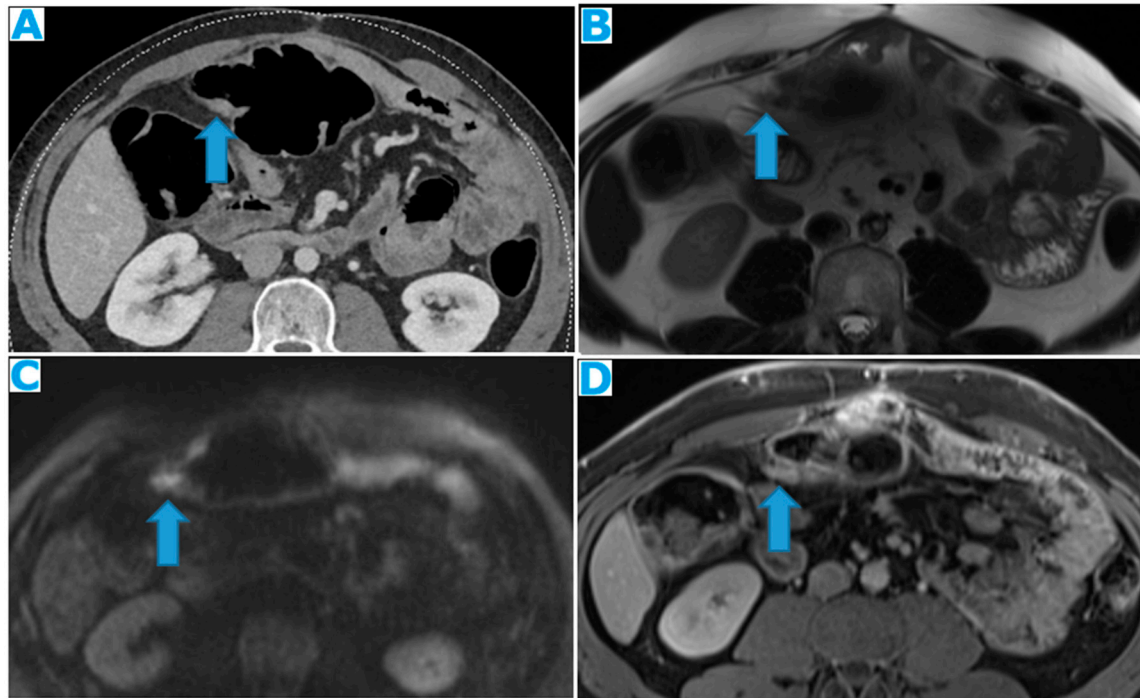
Axial CE-CT (A), axial T2WI (B), DWI (C), axial CE portal phase FST1WI (D). PC from gastric adenocarcinoma: Subtle deposit within the transverse mesocolon on CT, more conspicuous on MR.
